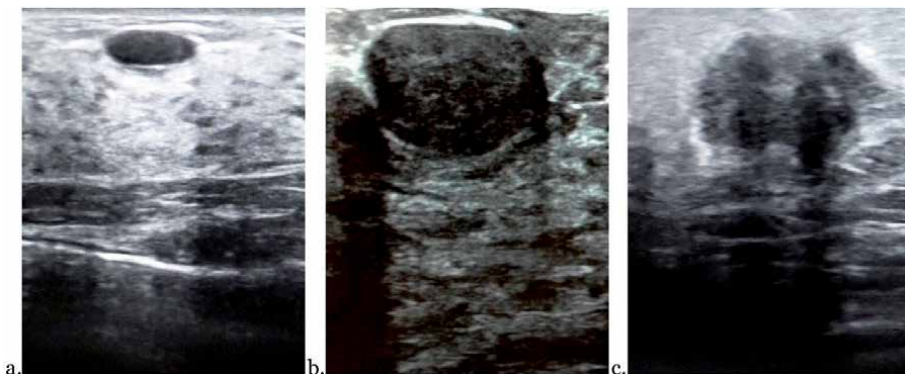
Ultrasound characteristics of breast lesions. (a) Circumscribed, oval, anechoic mass with parallel orientation and posterior enhancement consistent with a simple cyst. (b) Circumscribed, round, heterogeneous mass with lateral shadowing. The pathological diagnosis by biopsy was Fibroadenoma. (c) Irregular, noncircumscribed, hypoechoic mass with posterior shadowing: Invasive Breast Carcinoma by biopsy.*
